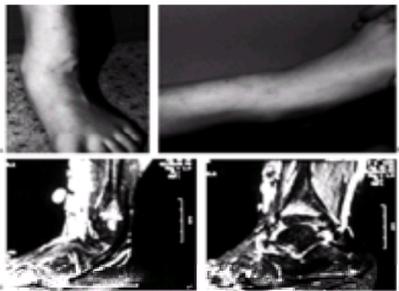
Eight-year-old girl with vascular malformation complaining of aching discomfort above the ankle. A: Standing clinical photograph demonstrating swelling and superficial irregularity over the anterolateral aspect of the ankle. This was nontender and easily compressible. B: With elevation of the limb, the lesion drained and was not palpable except for deep thick structures. C: MRI demonstrating high T2 signal typical of a vascular malformation.
